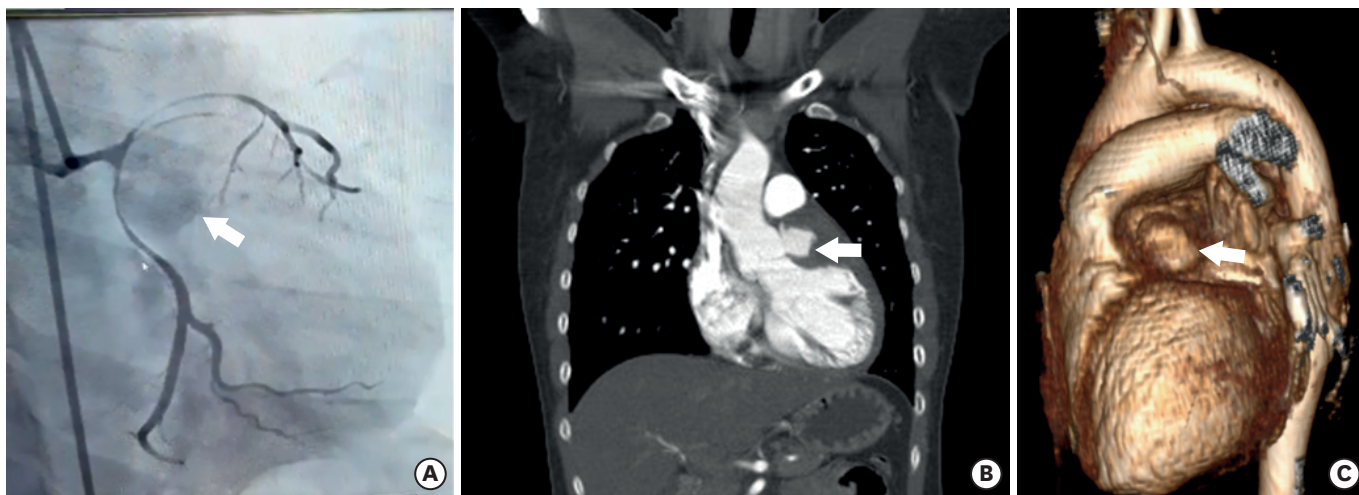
Preoperative imaging study of the patient. (A) Coronary angiography and (B, C) computed tomography of the patient.
